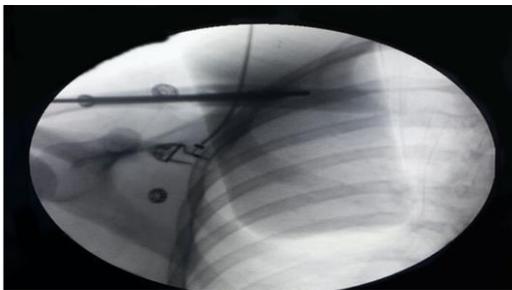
Intraoperative fluoroscopic x-ray: assessment of the final position of the screw (cephalic tilt view)
